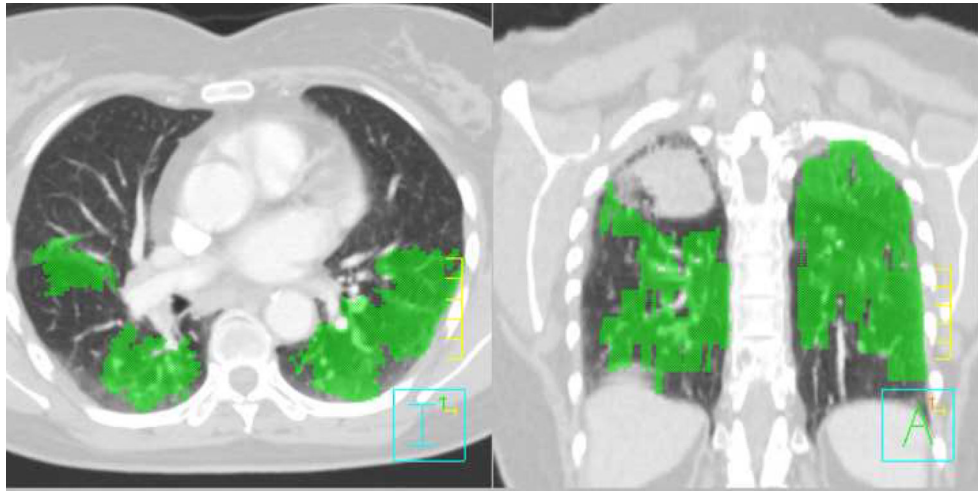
The areas shown in green color wash signify areas that are active in gas exchange that have been projected onto the treatment planning CT from the HPH-MRI data set.
